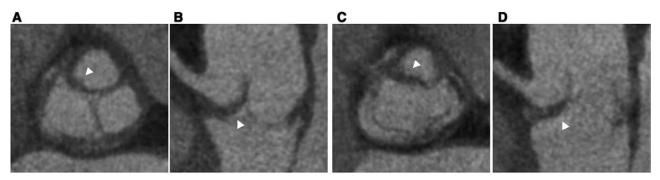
Structural valve deterioration computed tomographic (CT) images of a Sorin Freedom Solo stentless 23-mm bioprosthesis in aortic position. Note the thickening of the right coronary cusp (arrowheads) presented in systole (A and B) and the in diastole (C and D) with leaflet opening restriction.
